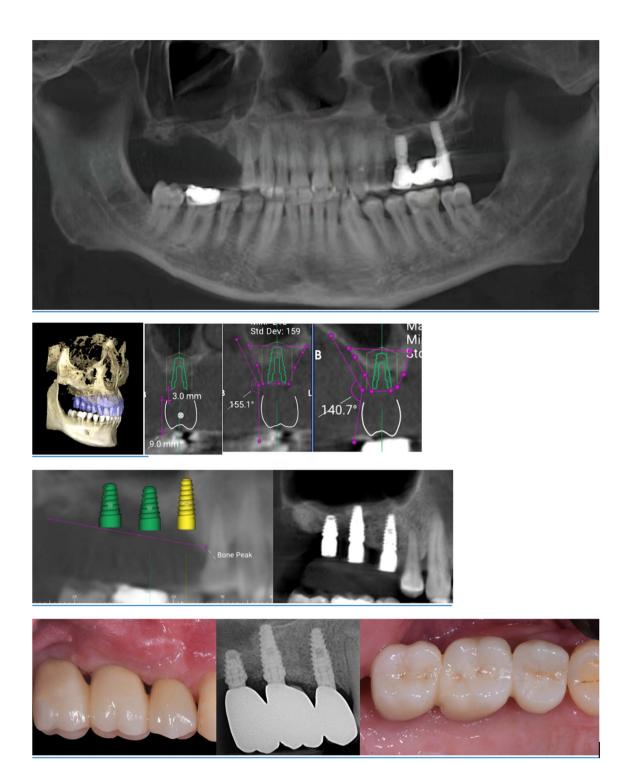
The Digital Surgical Planning (DSP) Protocol: CBCT scans are superimposed to the intraoral scans to produce a virtual wax-up, the future prosthetic restoration is planned in the ideal place, then implants are placed according to the position of the prosthetic restoration. Additional hard and soft tissue grafting are then planned.
